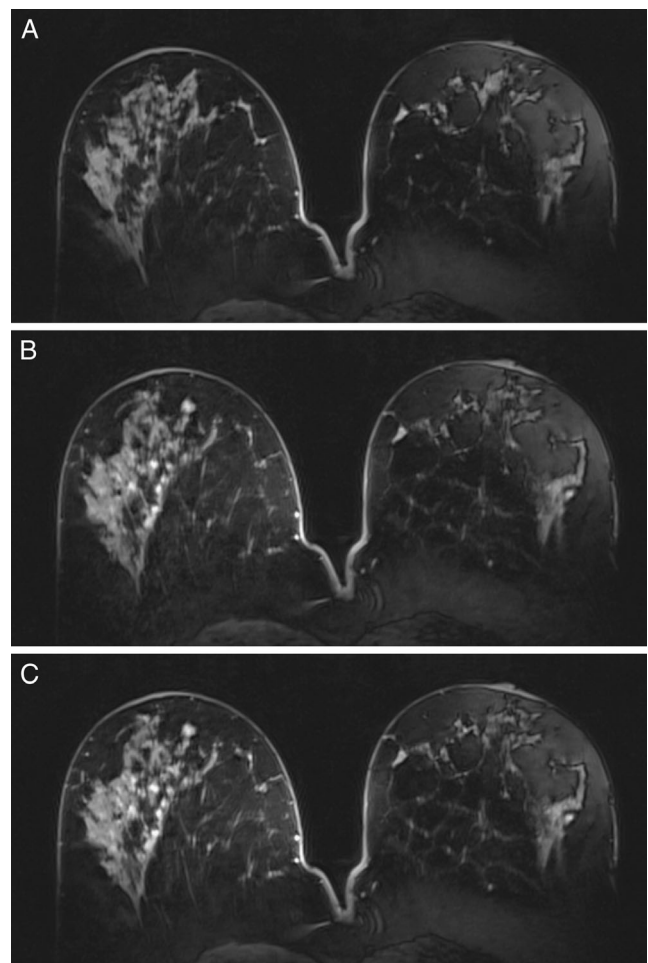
High-grade ductal carcinoma in situ in a 55-year-old woman, centrally in the right breast. a–c HR DCE-MRI of the breast at 7 T shows an asymmetric, regional, clumped, non-mass-like enhancement centrally in the right breast, which is correctly classified as BI-RADS[®] 4 (suspicious) by all readers
